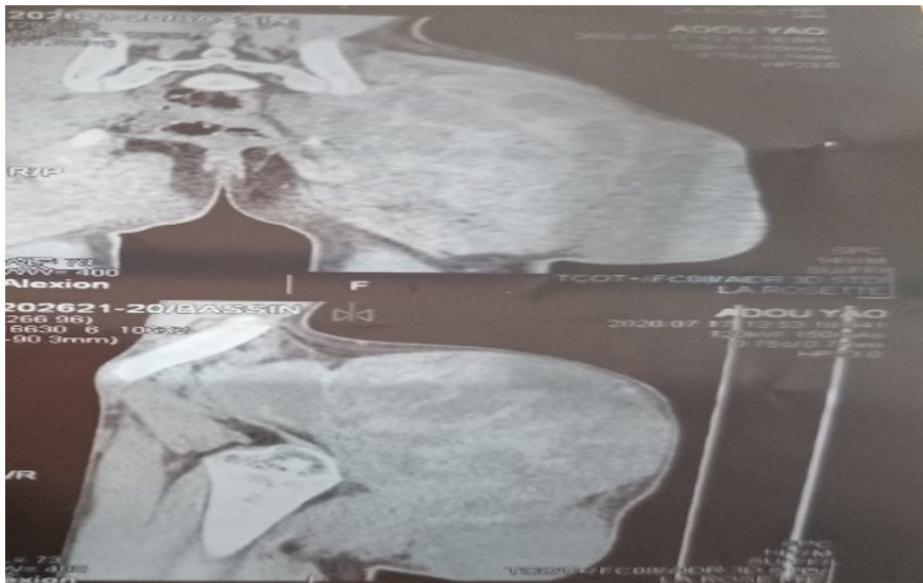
MRI frontal and sagittal sections of a tumor of the left buttock
